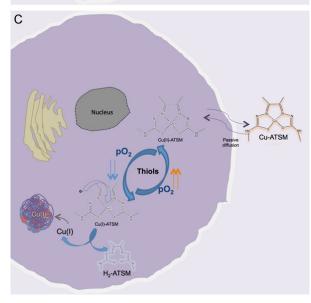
Overview of the uptake and retention mechanisms of FDG (A), F-MISO (B), and Cu-ATSM (C) in living cells under hypoxic conditions. For FDG there is a wide overlap between the cellular uptake in normoxic (Warburg effect) and hypoxic conditions (Pasteur effect). For the other two tracers, after passive diffusion through the membrane, the radiopharmaceutical is retained according to the oxygen tension (pO<sub>o</sub>) present in the intracellular environment: in the presence of reduced pO<sub>2</sub>, F-MISO undergoes progressive reduction by the nitroreductase enzyme (NTR); also, Cu(II)-ATSM nuclide is reduced to copper (I) by the intracellular thiols, making the Cu-ATSM complex less stable. Both processes are reversible in the presence of sufficient O2, and the molecules (F-MISO and Cu (II)-ATSM) are free to leave the cell. Conversely, in hypoxic conditions the Cu(I)-ATSM complex is progressively dissociated, with the formation of H<sub>2</sub>-ATSM and free Cu(I), which is very rapidly incorporated into intracellular proteins. In contrast, the reduced F-MISO is covalently bound to the intracellular proteins [59, 84, 122, 128]. GLUT, glucose transporter; HK, hexokinase; G-6-P, glucose-6-phosphate).
